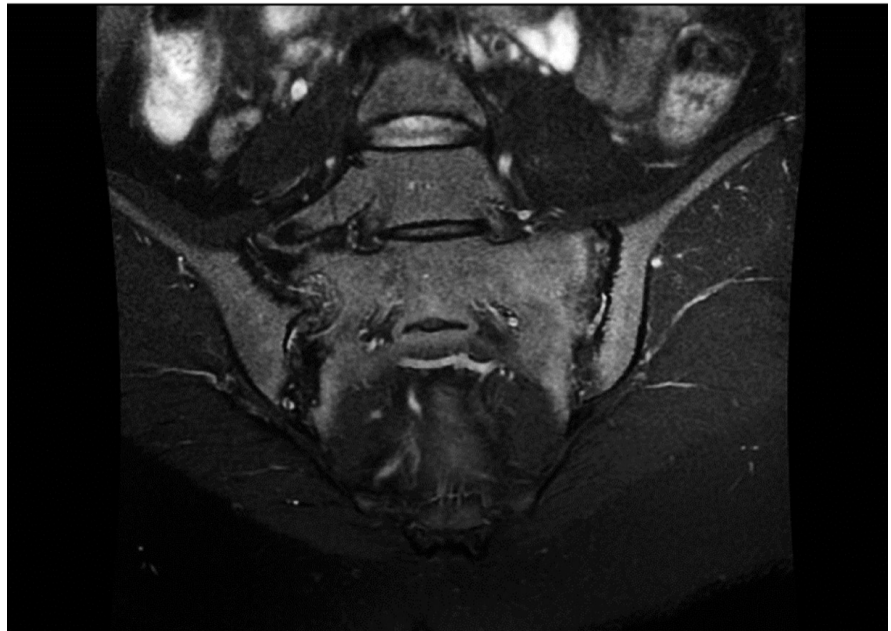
MRI: sacroiliac joints; T2 sequence: bilateral bone oedema on the sacral side.
